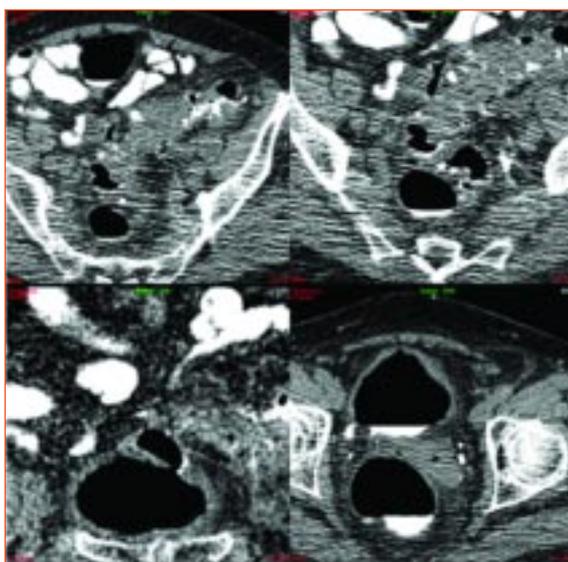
Axial CT images in an 84-year old lady who underwent virtual colonoscopy showing a colovesical fistula secondary to extensive sigmoid diverticular disease.
